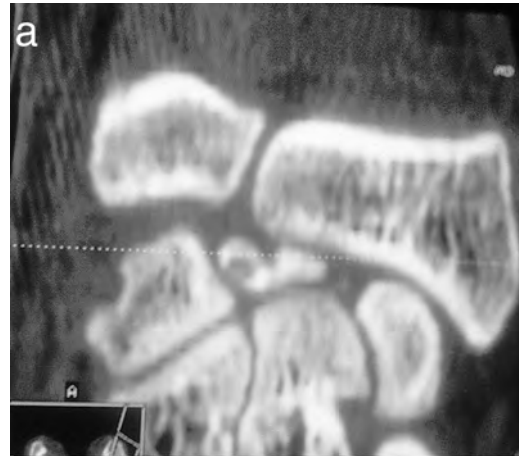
(a) CT scan image of a late stage III case showing complete destruction of the lunate. A preoperative arthroscopy revealed intact lunate cartilage. (b) Postoperative X-ray at 9 years follow-up showing satisfactory revascularization of the lunate with a particular shape of the lunate. The patient was pain-free with only terminal loss of wrist extension.
